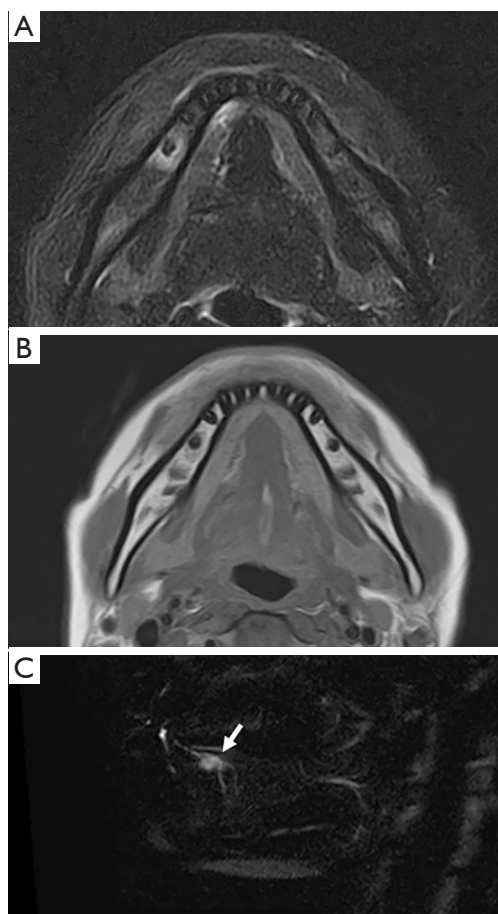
Identification of ranula derived from the Bartholin duct in patients with ranula on MR sialography. STIR (A), T1-weighted images (B), and MR sialography (C) in a 15-year-old woman with ranula in the right oral floor. A mass lesion is seen in continuity with the sublingual glands on STIR (A) and T1-weighted images (B), and was diagnosed as ranula. The mass is derived from the Bartholin duct as one bright homogeneous linear structure (arrow) (C). MR, magnetic resonance; STIR, short-tau inversion recovery.
